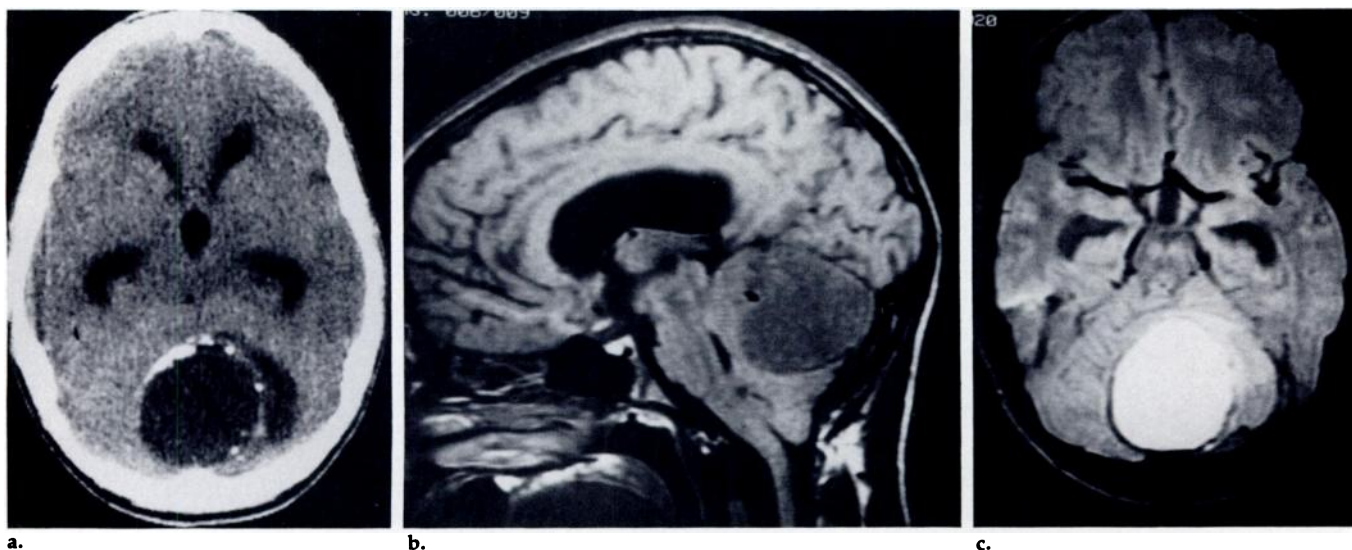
Old hemorrhage in the cyst of a cerebellar astrocytoma in a 13-year-old boy. (a) Unenhanced CT scan. The astrocytoma is shown infiltrating the left cerebellar hemisphere, with a large midline cyst with anterior and left-sided calcifications. There are no calcifications in the right posterolateral cyst margin. (b) Sagittal T1-WI (TR, 800 msec; TE, 20 msec). The cyst is slightly hypointense to gray matter. (c) Axial T2-WI (TR, 2,000 msec; TE, 40 msec). The cyst fluid is hyperintense. Note the nondiscernibility of the calcium and the peripheral ring of hypointensity where the cyst abuts normal parenchyma rather than tumor.
